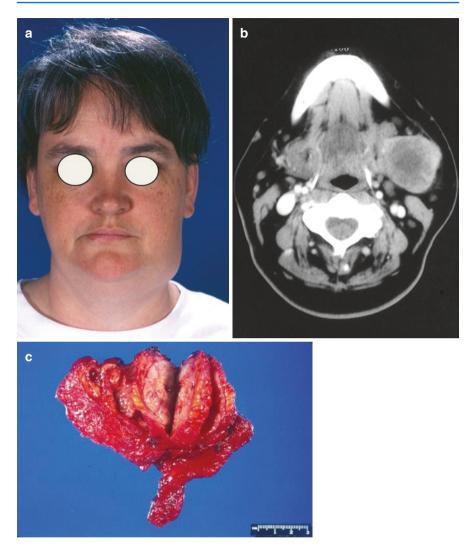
(a) The patient presented with an enlarging submandibular mass suspicious for malignancy. (b) CT scan with contrast revealed a heterogeneously enhancing mass of the submandibular gland that did not appear to be locally invasive. (c) The tumor was completely excised with a level I lymph node dissection, and final pathology revealed carcinosarcoma of the submandibular gland with no positive lymph nodes or perineural invasion
